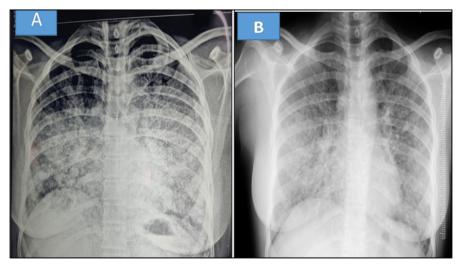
(A) Shows chest X-ray taken at the time of presentation and (B) after three sessions of whole lung lavage.
